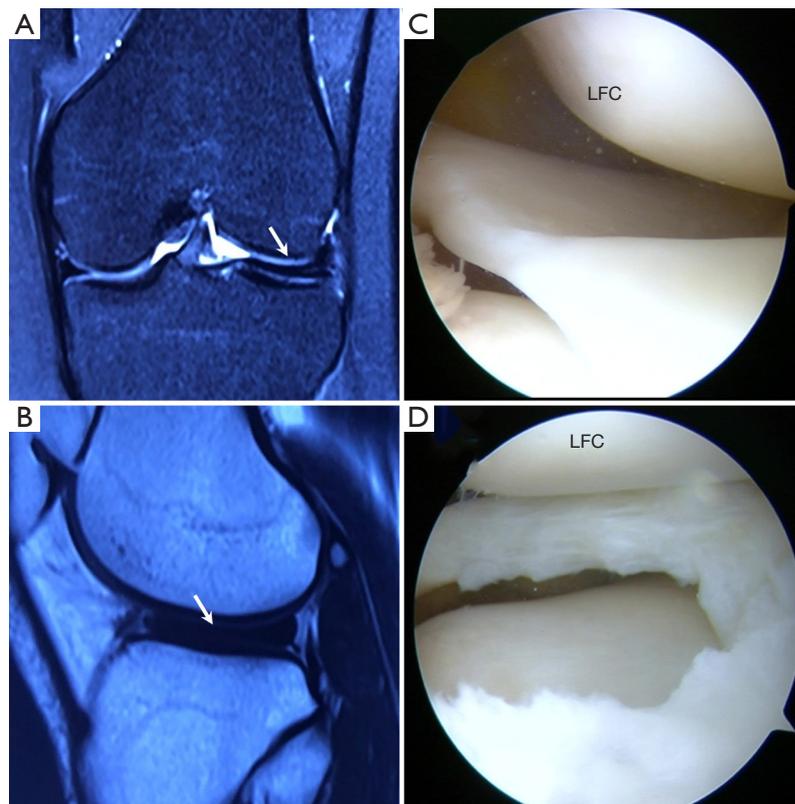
The MRI and arthroscopic findings of DLM and outcomes after DLSM. (A) The magnetic resonance imaging on the coronal plane, the white arrow indicated the DLM; (B) the magnetic resonance imaging on the sagittal plane, the white arrow indicated the DLM; (C) arthroscopic findings of the DLM; (D) the DLSM was performed arthroscopically. DLM, discoid lateral meniscus; DLSM, discoid lateral subtotal meniscectomy; LFC, lateral femoral condyle.
